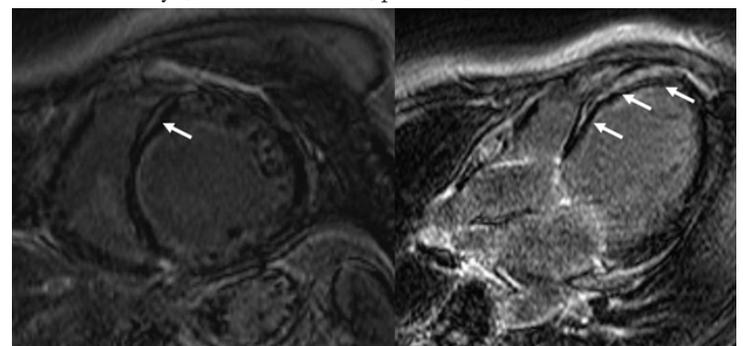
Assessment of myocardial fibrosis with LGE-MRI in dilated ischemic cardiomyopathy. A 53 year-old male with dilated cardiomyopathy and midwall fibrosis extending along the septum (arrows)
